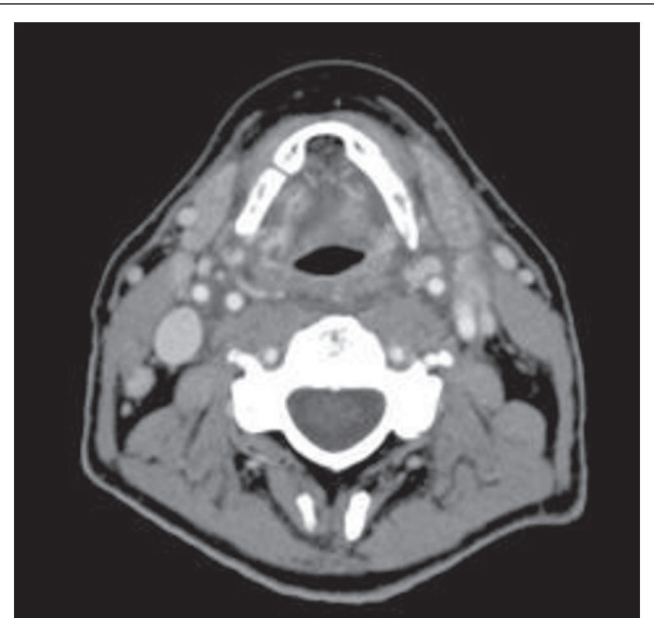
This 52-year-old patient received chemoradiotherapy (70 Gy at 2 Gy/fraction every day with fluorouracil/cisplatin) for T3N2b tonsil cancer. Post-radiotherapy computed tomography demonstrated a 1.7-cm lymph node with probable (grade 3) focal enhancement in the left neck at level II. Neck dissection was positive, with extracapsular extension. The patient was controlled with 4 years of follow-up.
